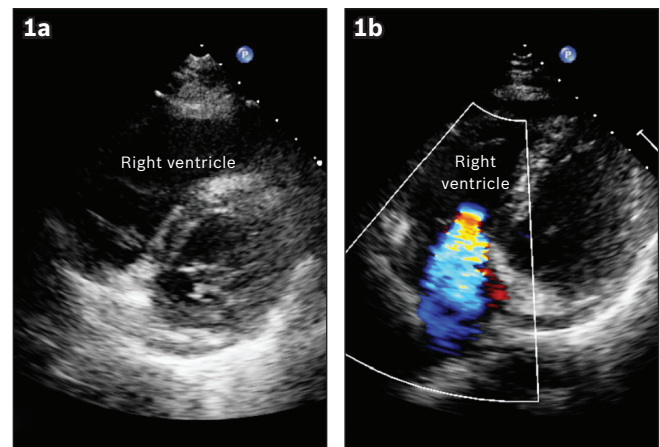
Echocardiography images show (a) dilatation of the right ventricle and (b) severe tricuspid regurgitation.
